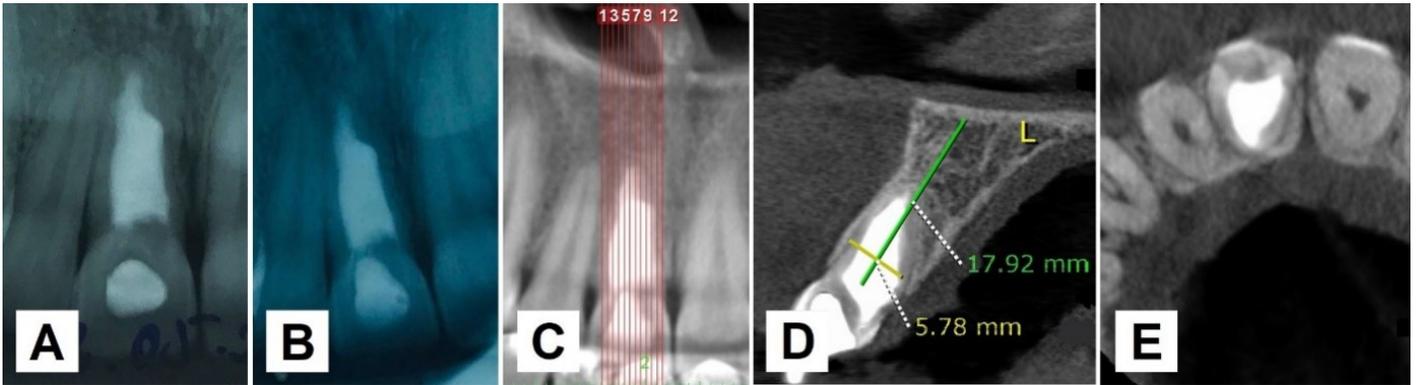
(A) periapical radiography of 2-years follow-up. (B) periapical radiography of 10-years follow-up. (C-D-E) Cone beam computed tomography in coronal, sagittal and axial planes with 10-years of follow-up. Note the complete healing of the periodontal structures and the paralization of the resorptive process.
